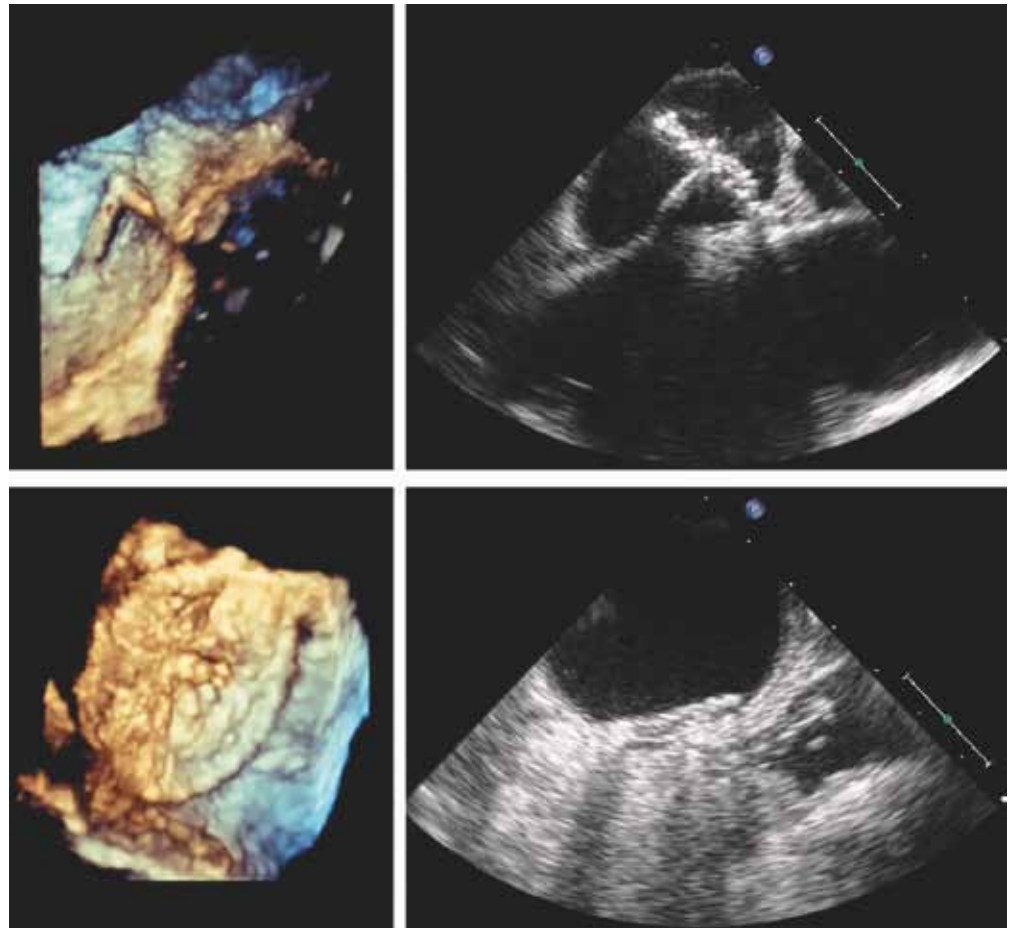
Echocardiographic views. Left upper: Three-D Echocardiography showing the guidewire passing through the PFO; Right upper: Two-D Echocardiography showing the left atrial disc opened; Left Bottom: Three-D Echocardiography showing the left atrial disc placed on the left atrial aspect of the interatrial septum; Right bottom: Two-D Echocardiography with contrast injection showing a properly placed device and no residual shunting.
